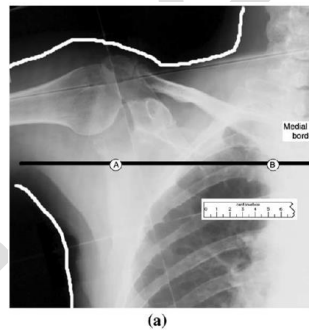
Frontal view (radiograph) of axillary region. Dose specification points A and B are indicated. The axial patient contour given in (b) is indicated by a black line. (b) Axial contour at the cranio-caudal level of the black line indicated in (a).
